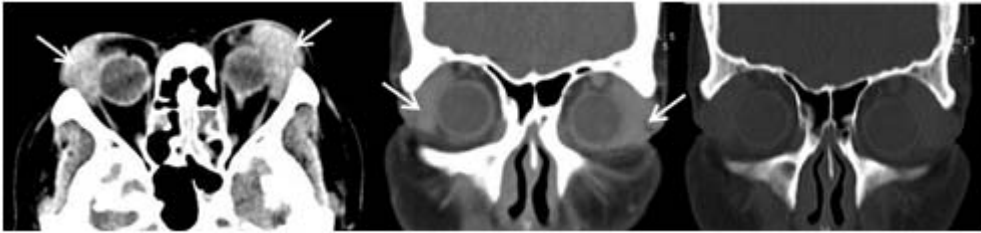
Lacrimal gland lymphoma. Non-enhanced axial and post contrast-enhanced coronal CT scan revealed bilateral lacrimal gland enlargement (arrow) with involvement of bilateral lateral rectus muscles. Both lacrimal glands were hyperdense to muscle. There was no bony destruction.
